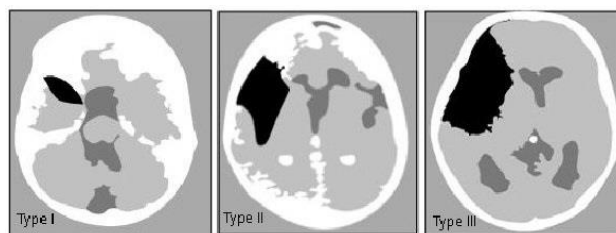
CT classification of Sylvian fissure arachnoid cysts⁵
